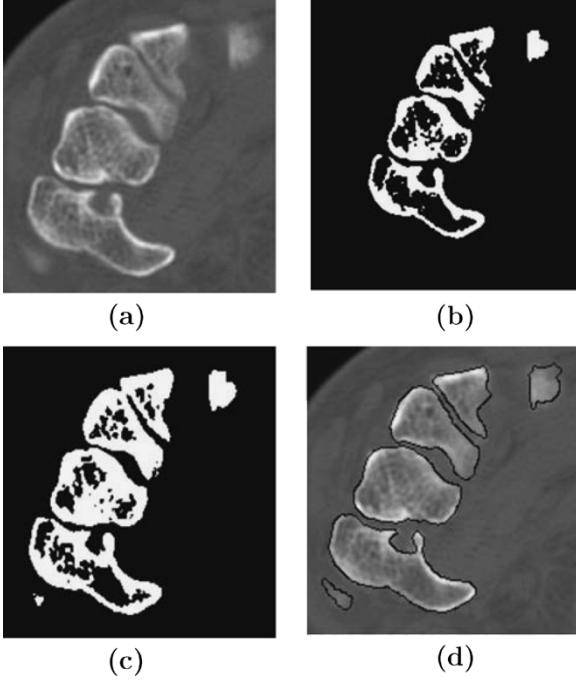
Comparison of the segmentation by global thresholding and our algorithm. (a) The original CT slice. (b) The segmentation using a global threshold of 360. (c) The same as (b), using a global threshold of 250. (d) The edge map computed with our algorithm.
